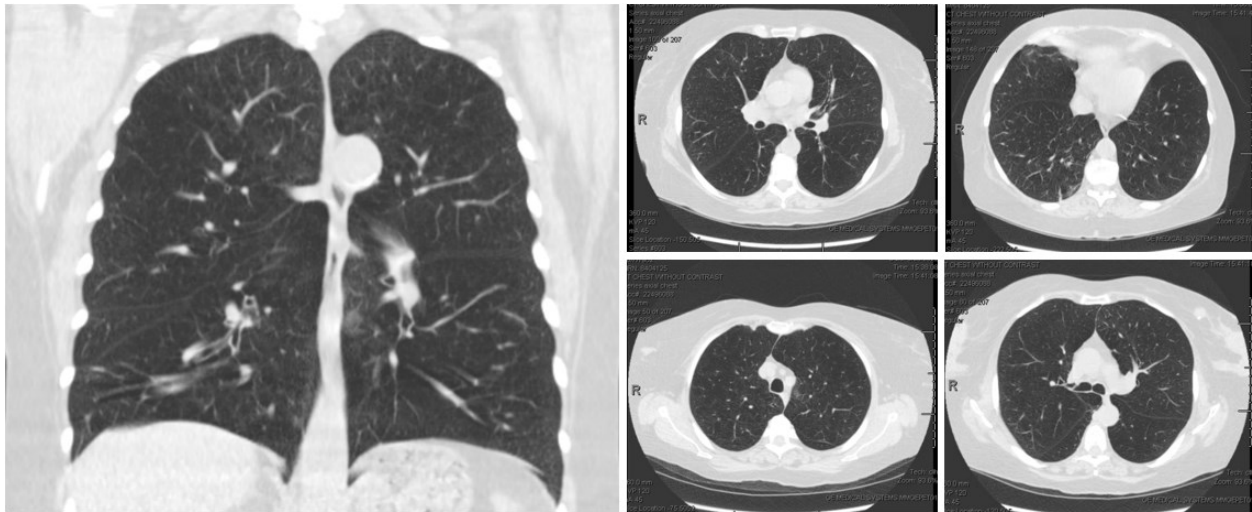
Case 1 - Computed Tomography Chest Pre-BLVR
